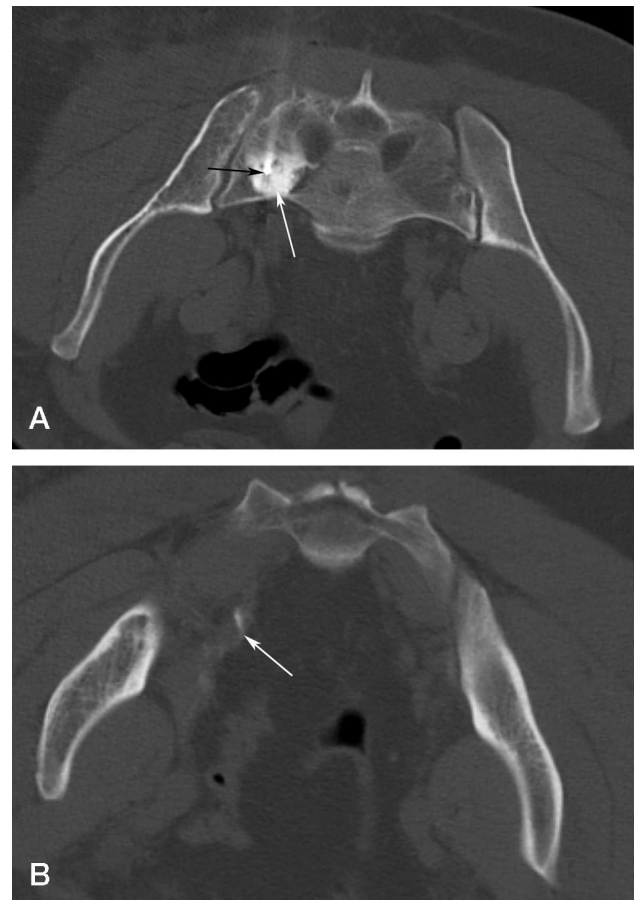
Computed tomographic images of the sacrum (A) and the pelvis (B) obtained after injection of contrast medium into the sacral lytic lesion. Note the presence of contrast within the lesion and also note the presence of contrast medium extravasation in the pelvic soft tissues (white arrows). The tip of the needle (black arrow) used for osteoplasty is situated within the center of the lytic lesion (A).
